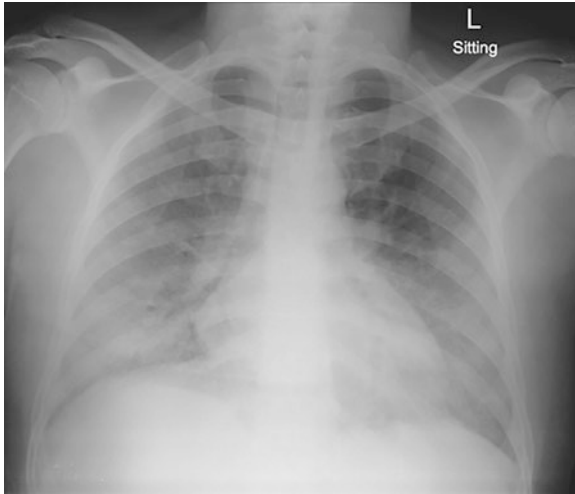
The above figure shows that on arrival, the patient's chest radiograph revealed bilateral ground-glass opacifications, mostly in the lower zone. The patient was started on empiric dexamethasone and therapeutic co-trimoxazole after a working diagnosis of COVID-19 and/or PCP. On the third day of hospitalization, however, persistent fever, hemodynamic instability, increased oxygen needs with worsening pulmonary infiltrates on chest X-ray, and growing inflammatory markers led to a diagnosis of nosocomial pneumonia. In the absence of culture findings, empiric meropenem and fluconazole were started, reproduced with permission [28]
